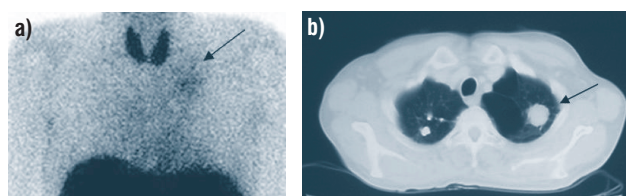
Findings in patient with adenocarcinoma of the lung: a) round tumor mass in the left upper lobe (arrow) and two small nodules in the right upper lobe on CT; b) increased uptake of ^{99m}Tc -sestamibi in the left upper lobe (arrow); no uptake in the nodules in the right upper lobe.
